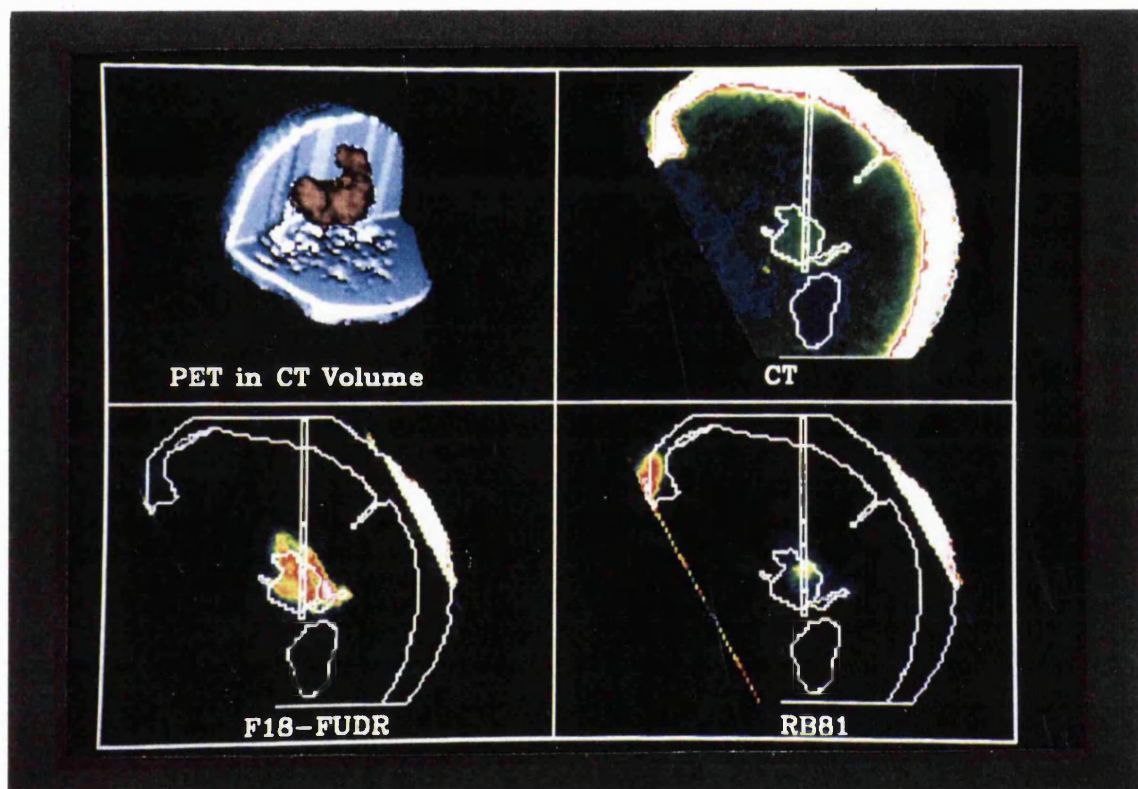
Case 1: Correlated contrast CT, (F18-FUDR)PET and (Rb81)PET. Images reconstructed along biopsy trajectory. (CT boundary overlaid on PET images)
